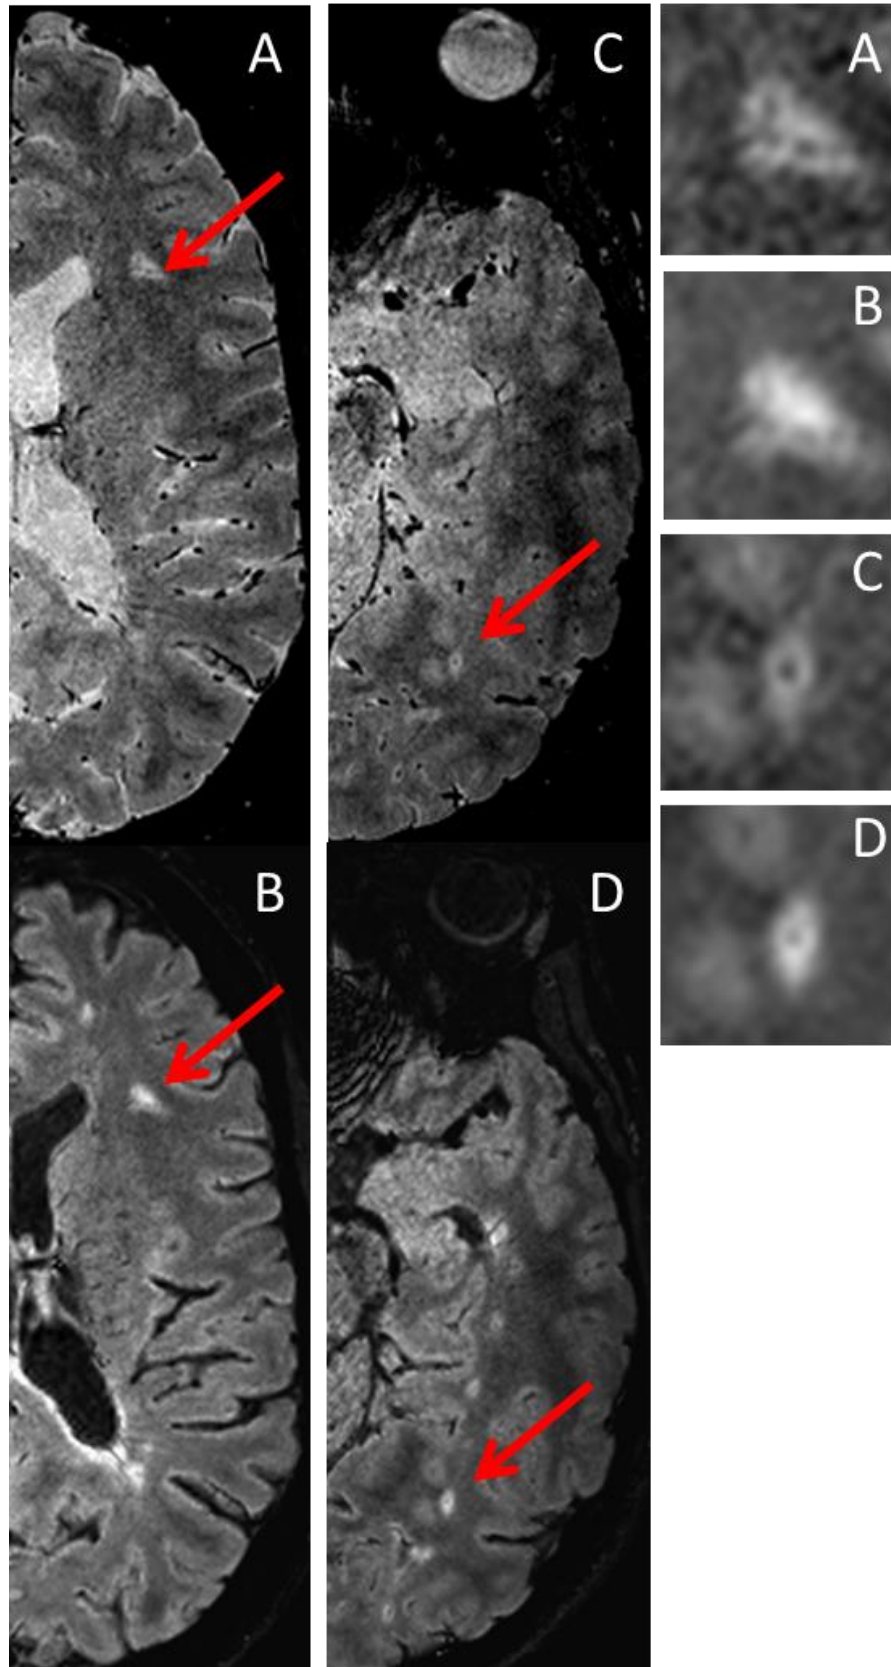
A comparison of T2* hEPI and FLAIR-SWI-2.
